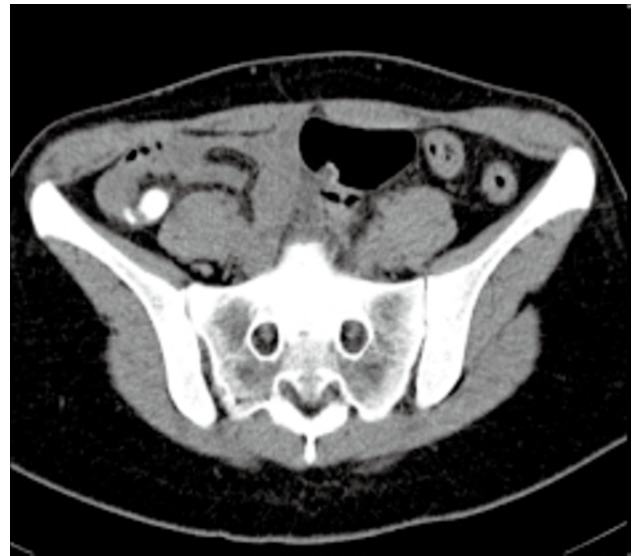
Pelvic CT with two calcified masses in enlarged non-inflamed appendix. This figure shows, on computed tomography (CT), a calcified density in the right abdomen.
